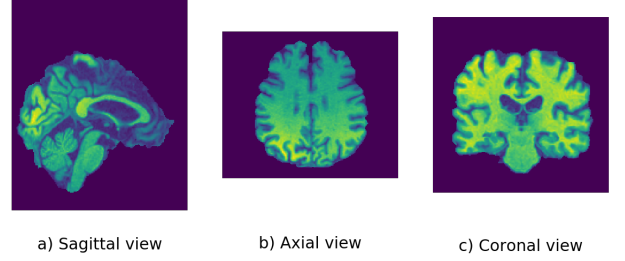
Sagittal View, Coronal View and Axial View of MRI image
